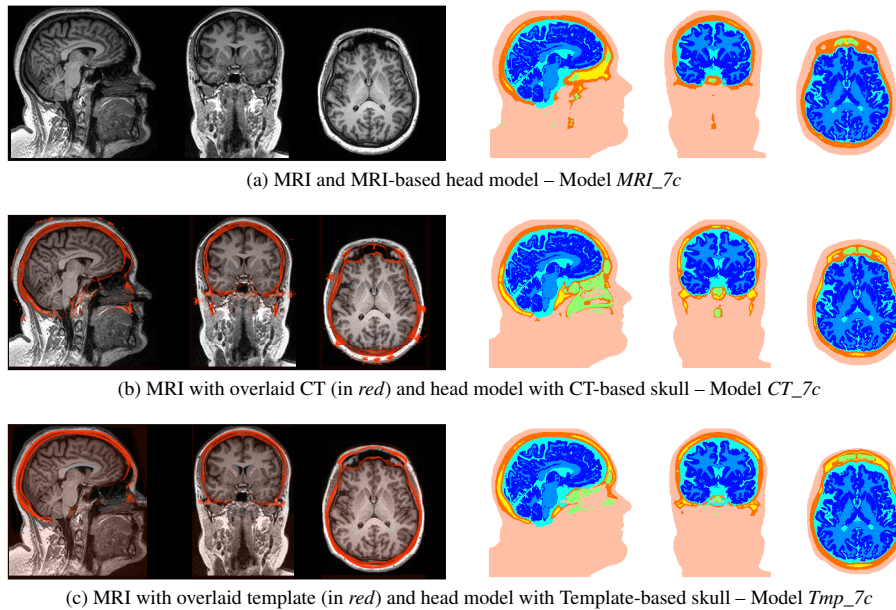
MRI of patient 1 with combined modalities for skull segmentation (left column). The head models on the right column show seven different tissue types: Scalp, Compact bone, Spongy bone, Air cavities, CSF, WM and GM.
